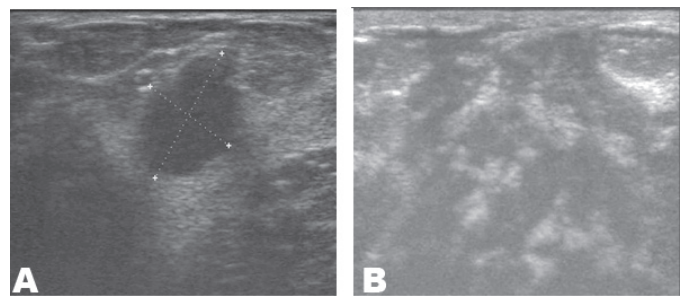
(A, B) Left breast ultrasound showing a round to oval shaped hypoechoic mass which demonstrates through transmission with no calcifications. The lesion measures 2.2x1.5 cm in size on transverse view on its widest diameter.
